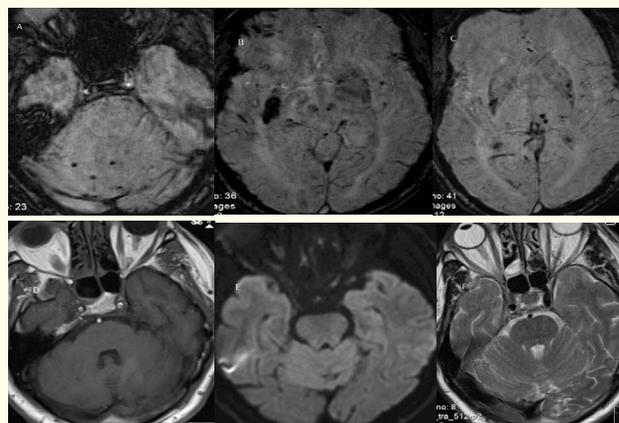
Bilateral basal ganglions and milimetric microhemorrhage foci creating sensitivity artefacts in the thalamus, left half of the pons, left cerebral peduncle and right cerebellum are observed in the SWI sequence (A, B, C). Existing foci cannot be distinguished on T1 axial, DWI and T2 axial sequences (D, E, F).
